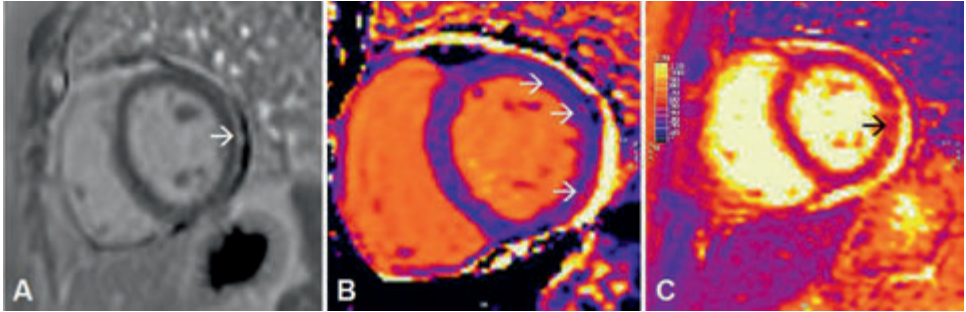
Abnormalities on cardiac magnetic resonance imaging (CMR) consistent with (peri)myocarditis in a patient with non-specific myositis/overlap myositis in the setting of a mixed connective tissue disease
